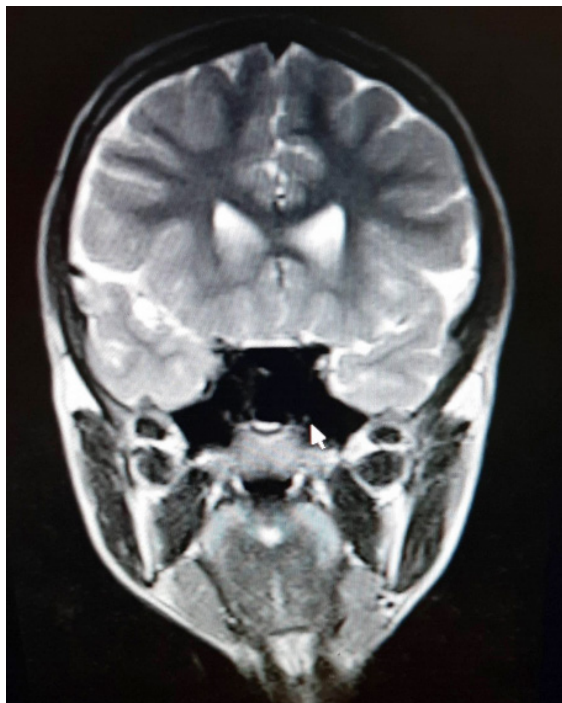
Magnetic resonance imaging (MRI) revealed the diagnosis of pneumosinus dilatans of sphenoid sinuses
